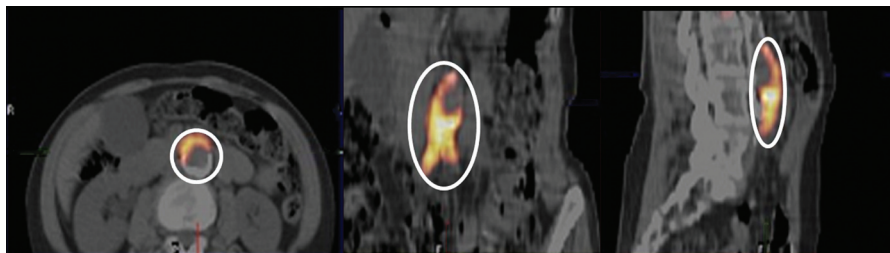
Quantification of FDG uptake. A volume of interest (VOI) was created by placing a marker around the site of maximal FDG uptake in all 3 dimensions. Subsequently, standardized uptake value was calculated by determining the maximal FDG concentration in this well defined volume.
